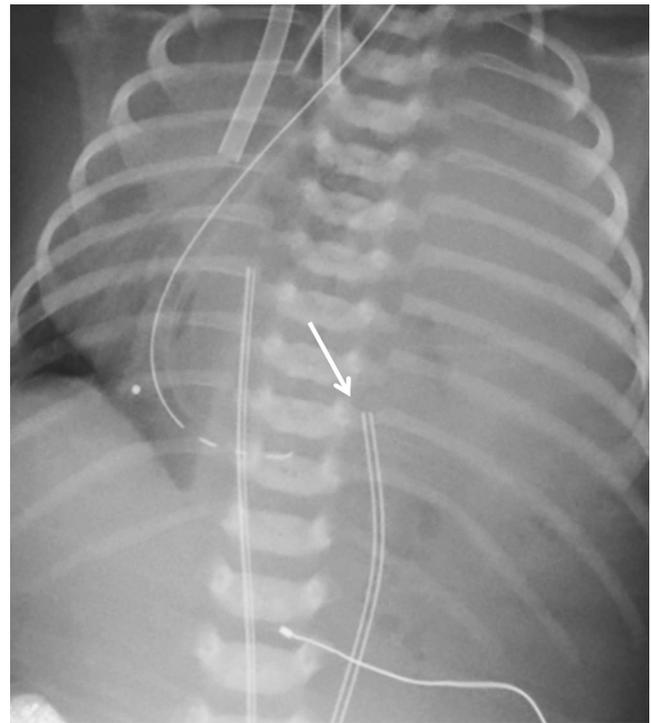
Anteroposterior radiograph of the chest in a newborn boy. The radiology report excerpt was as follows: “The presumed UVC terminates in the right atrium.” The UVC (umbilical venous catheter) (*arrow*) is incorrectly identified as the umbilical arterial catheter. The UVC is actually to the left of the umbilical arterial catheter and is suboptimal in location, overlying the contralateral chest
